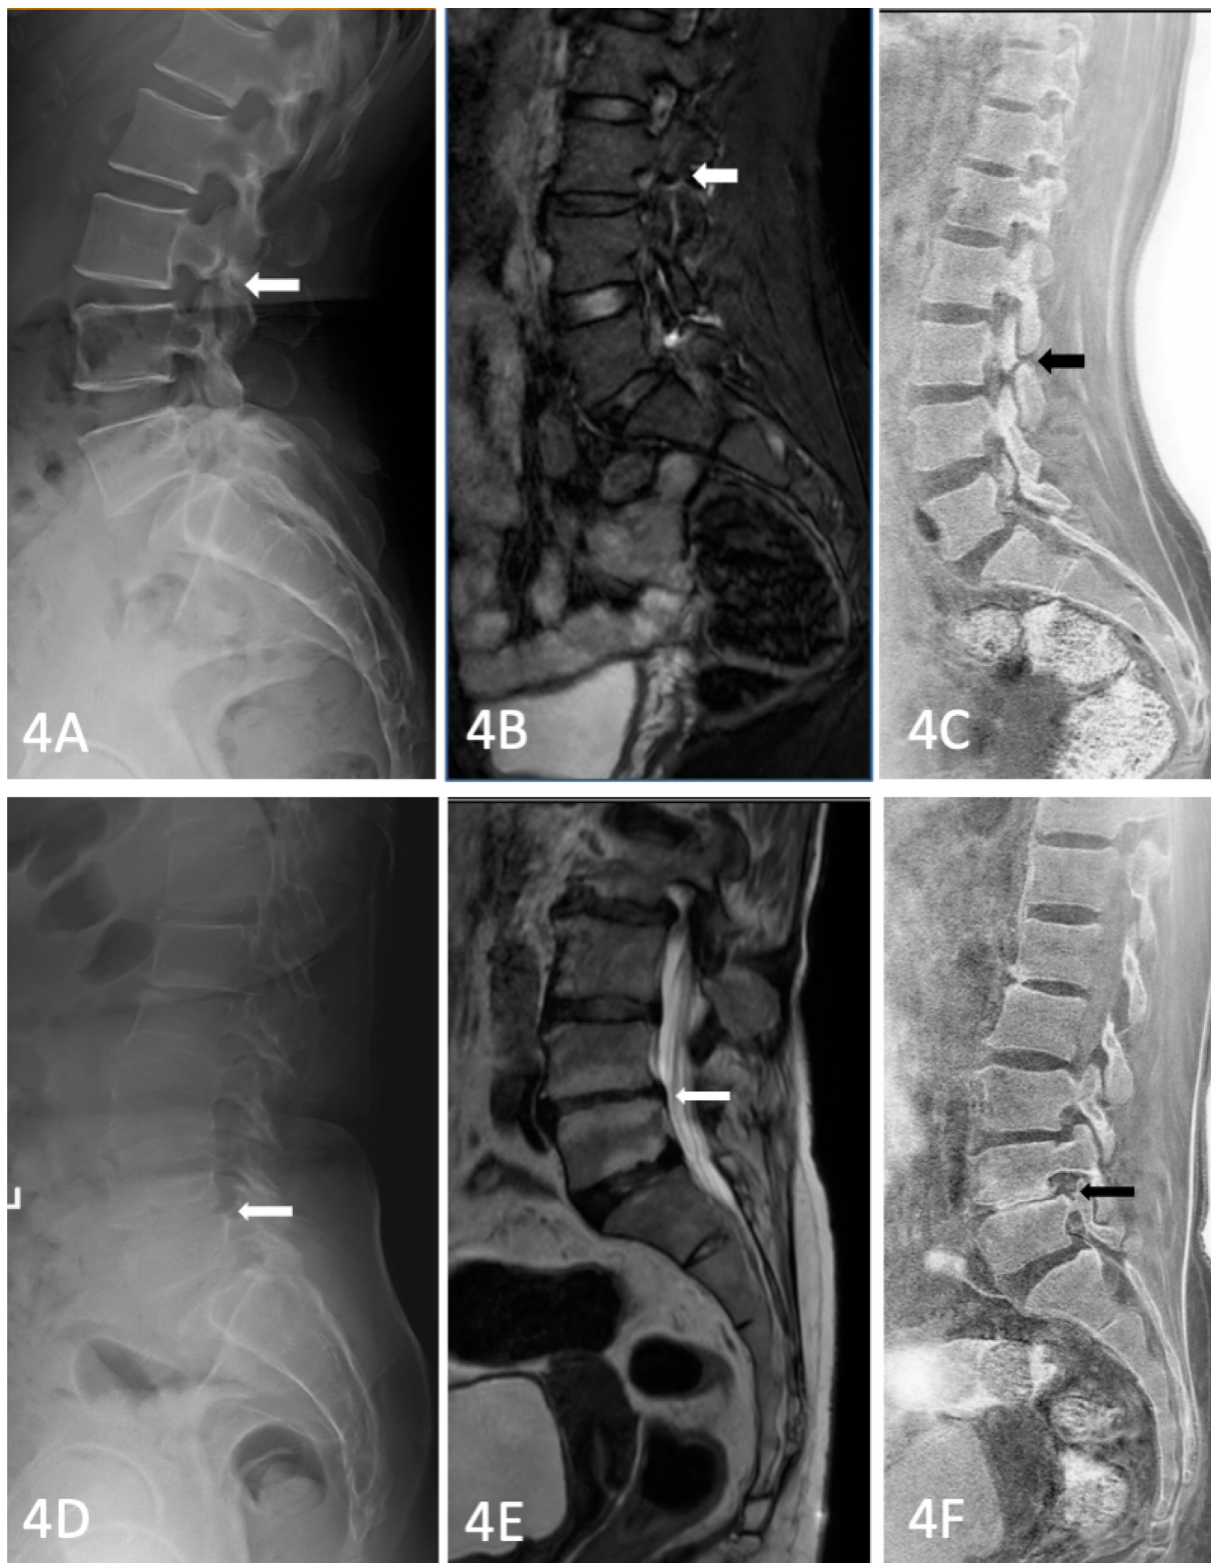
(A) Lateral lumbar radiograph showing spondylolysis at L3. (B) Sagittal T2-weighted MRI of the same patient. (C) Sagittal BTFE showing the pars defect with improved delineation (arrow). (D) Lateral lumbar radiograph showing L4–L5 Grade I spondylolisthesis. (E) Sagittal T2-weighted MRI of the same patient. (F) Sagittal BTFE showing Grade I L4–L5 spondylolisthesis with improved depiction of the bony endplates and pars (arrow).
